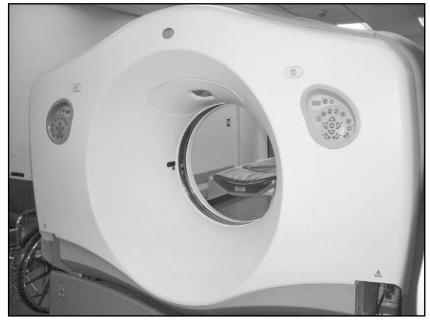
Computed tomography gantry, rear.
